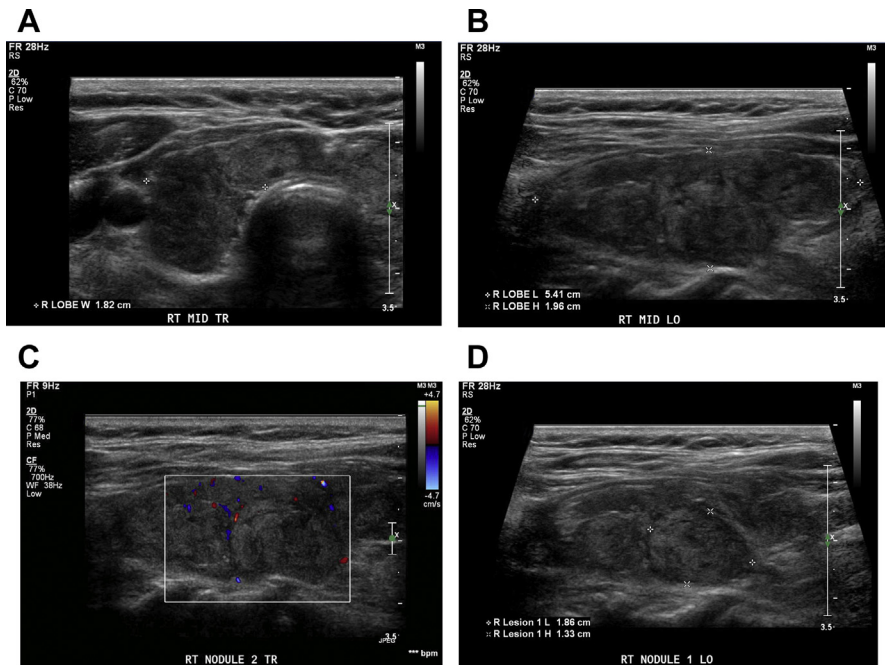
A 67-year-old woman with Hashimoto thyroiditis and discrete possible nodule. (A, B) Heterogeneous gland with hypoechoic nodules diffusely in the right lobe on gray-scale in the transverse (A) and longitudinal planes (B). (C) On color Doppler, there is little flow in the nodule and thyroid in this chronic phase. (D) Discrete 1.9-cm ACR TI-RADS TR-3 nodule was biopsied (before TI-RADS implementation); pathology was benign lymphocytic infiltration. Note that nodule measurement was made before ACR TI-RADS implementation in the longitudinal plane; note that TI-RADS nodule measurement requires only cranial-caudal measurement in the longitudinal plane, and both AP and transverse measurements should be obtained in the transverse plane, as in Fig. 3. Cursors on (A, B) represent thyroid lobe measurements in the transverse and longitudinal planes.
